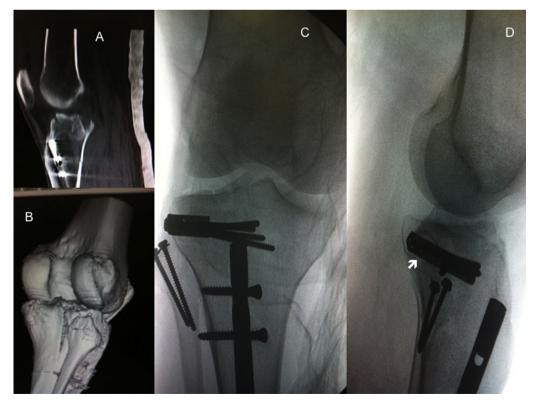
(A and B) CT scan showing posterior fracture of the tibial plateau in a patient with healed tibial shaft fracture treated by intramedullary nailing. (C and D) Postoperative images in anteroposterior and lateral views showing the horizontal plate with satisfactory reduction of the tibial plateau. Bone graft was necessary to fill the subchondral gap (white shadow). The fibular neck osteotomy was fixed with two lag screws.
